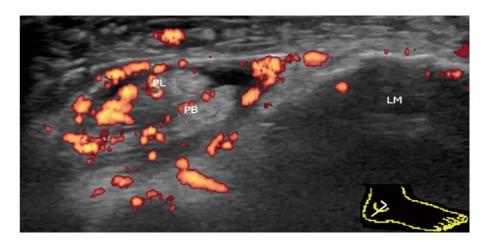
Proliferative tenosynovitis of the peroneus longus and brevis in rheumatoid arthritis. Transverse power Doppler sonogram through the lateral ankle at the level of the lateral malleolus shows thickening and marked hyperemia of the tenosynovium surrounding the peroneus longus and peroneus brevis. PL: Peroneus longus; PB: Peroneus brevis; LM: Lateral malleolus.
